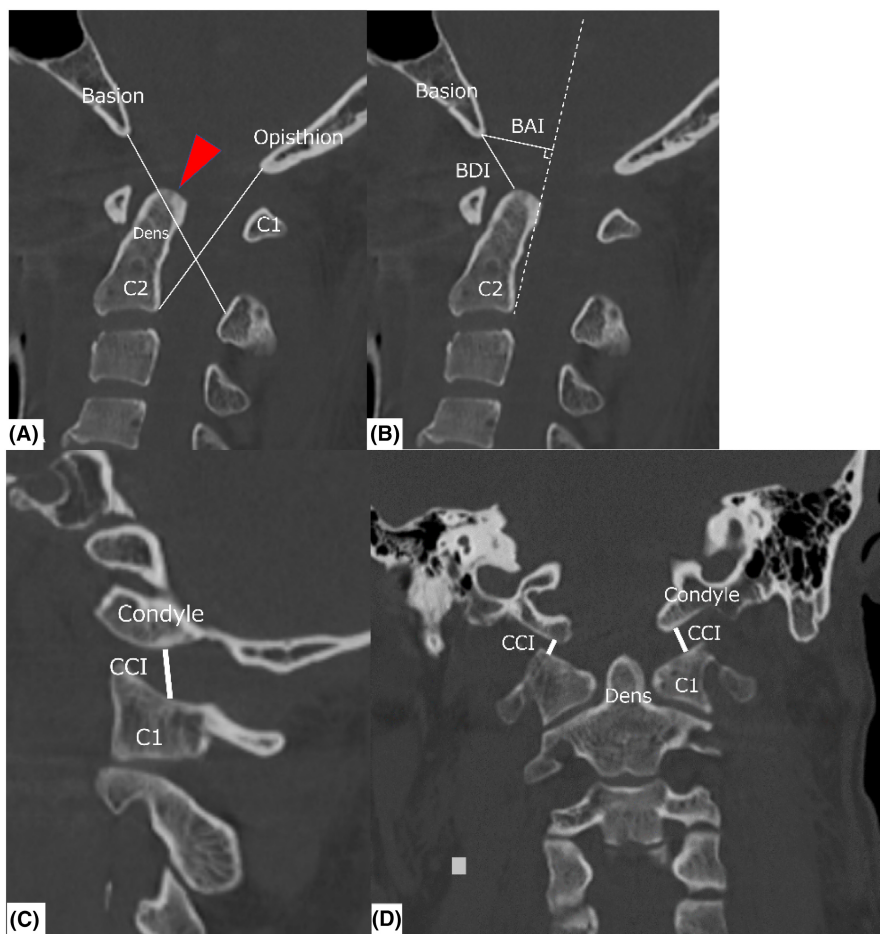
Preoperative cervical spine multi-detector CT. (A) X-line method: failure of a line from the basion to the axis spinolaminar junction to intersect C2, or a line from the opisthion to the posterior inferior corner of the body of the axis to intersect C1. In our case, both X limbs were displaced forward from the reference points. (B) Basion-dens interval (BDI): distance between basion and tip of dens. BAI (basion-axial interval): distance between the basion and posterior C2 lines. In our case, BDI was 19 mm, and BAI was 16 mm, indicating AOD (normal 12 mm). (C, D) Condyle-C1 interval (CCI): the distance between the occipital condyle and C1 lateral mass perpendicular from the surface of lateral mass to the surface of the occipital condyle. In our case, CCI is 13 mm on sagittal plane and 12 mm on coronal plane, indicating AOD (normal <4 mm).
